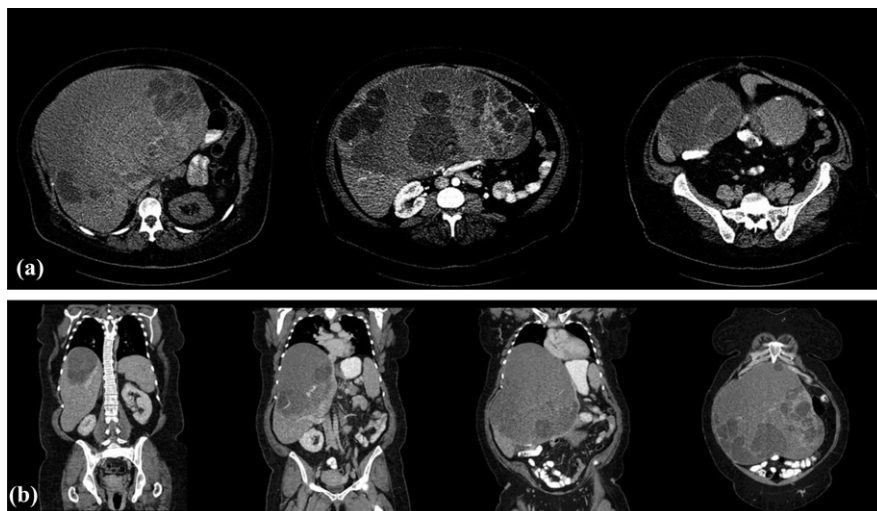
(a) Selected arterial-phase cross-sectional computed tomography images of biliary cystadenocarcinoma. (b) Venous-phase coronal reconstructions demonstrating a patent venous inflow and outflow of segments VI and VII
